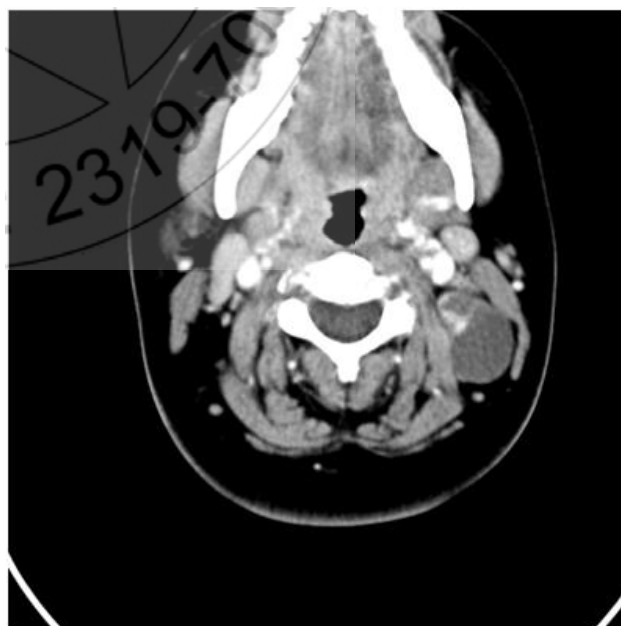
a: Axial CT-scan with contrast showed cystic mass with multiple reactive lymph nodes.
